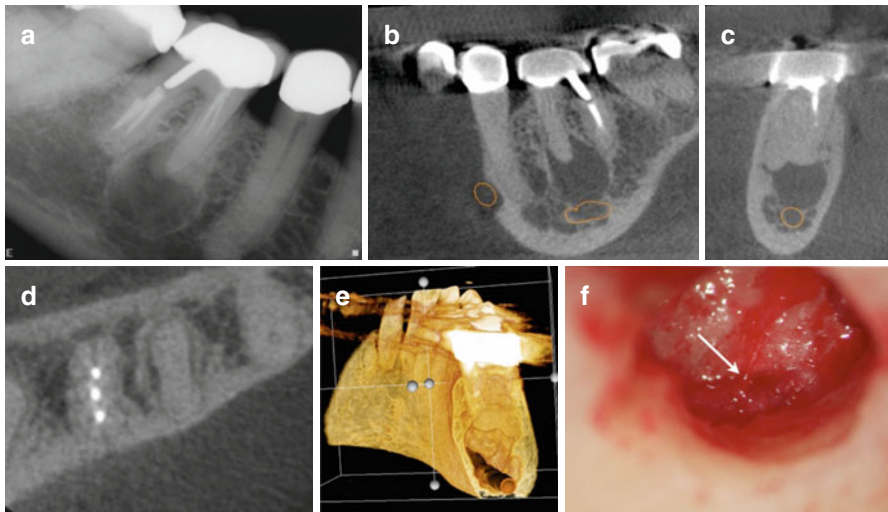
Periapical radiograph of tooth #30 that was referred for periapical surgery (a). CBCT of the sagittal, coronal, and axial views and 3D rendering demonstrating the proximity and communication of the defect and IAN to the mesial root of tooth #18 (b-e). Clinical picture after surgical flap reflection, mesial root resection, and degranulation of the defect (f). The IAN was detected (white arrow) at the base of the defect
